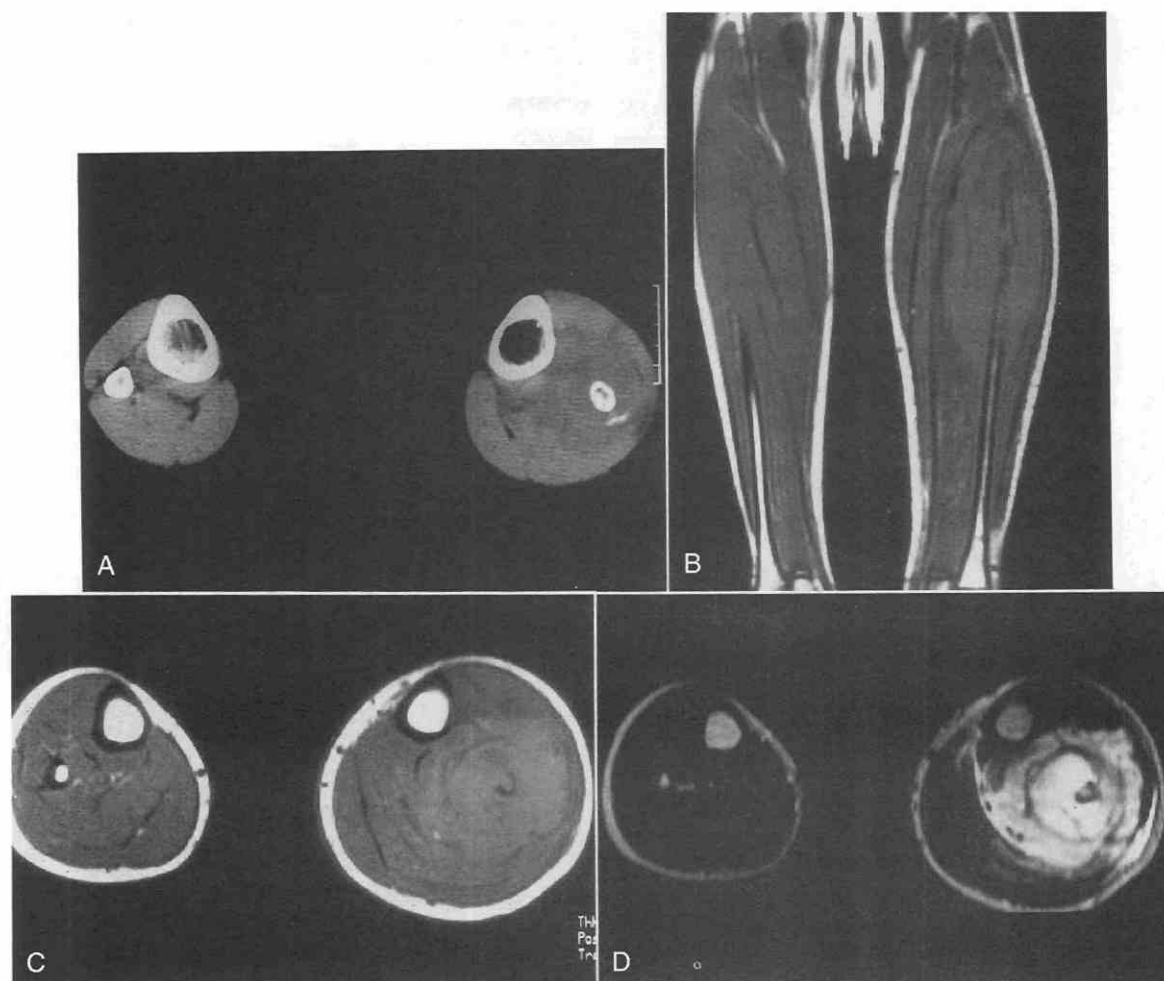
Ewing's sarcoma. *A*, CT scan reveals a large mass surrounding the left tibia. The mass reflects a density slightly lower than that of muscle. *B* and *C*, Coronal T1-weighted spin-echo image (TR = 700 msec, TE = 15 msec) (*B*) and axial T1-weighted spin-echo image (TR = 800 msec, TE = 15 msec) (*C*) demonstrate a large mass surrounding the fibula. This mass shows a signal intensity similar to that of muscle on the T1-weighted images in *B* and *C* and high signal intensity on an axial T2-weighted image (TR = 2500 msec, TE = 80 msec) (*D*).
